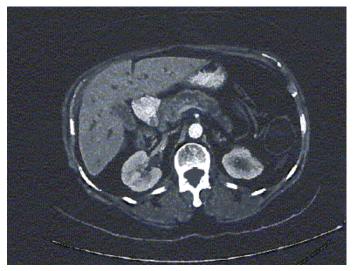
CT abdomen at the local hospital showed dilated intrahepatic ducts and common bile duct, pancreatic head mass.
